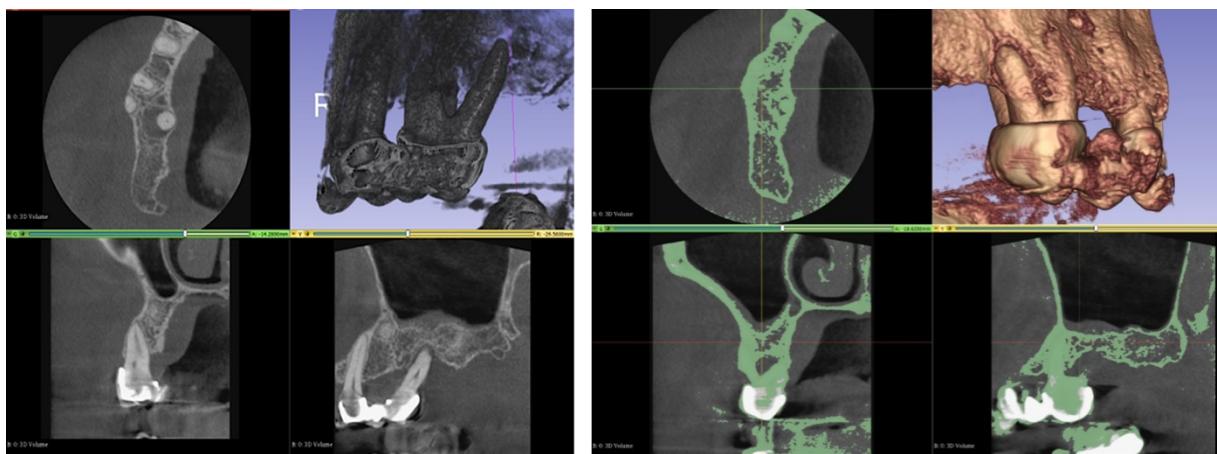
CBCT images are able to show the lesion more accurately than x-rays. Periapical x-ray (A), CBCT image (B) and segmented model (C).
